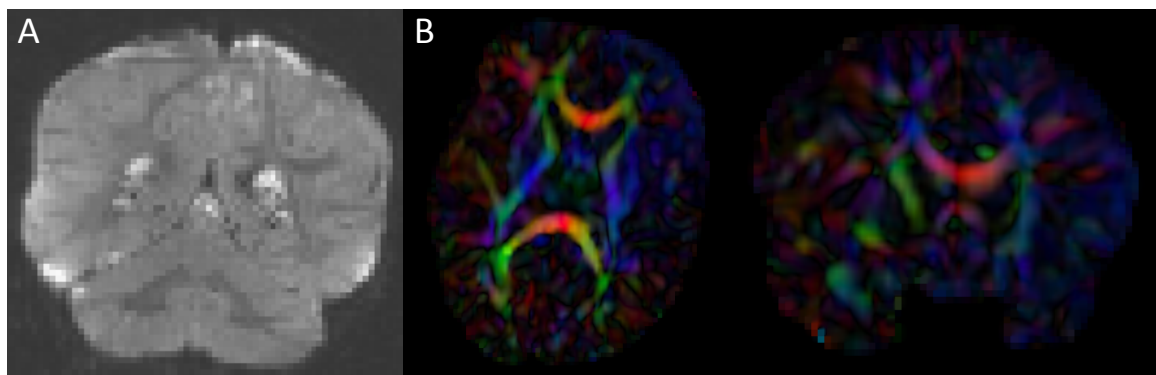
Artifacts encountered during quality control. A.) DWI artifact missed by automatic quality control run of DTIPrep, but caught in the visual quality control. You can see the horizontal lines running through this coronal view of the brain. Towards the top, almost an entire slice is missing. In cases like this, the gradient containing this artifact would be excluded from the saved DWI volume. B.) Axial and coronal view of DTI color FA volume. The large area of blue in the left frontal and temporal lobes indicates that a dominant direction artifact remains after DTIPrep quality control. Thus this artifact was too large to correct and this participant was excluded from analysis.
